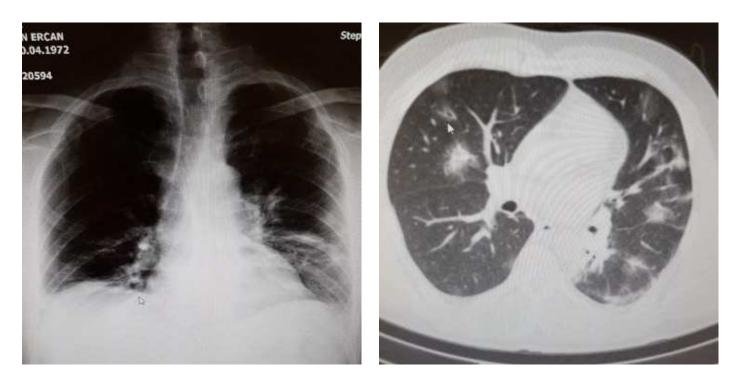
Hospitalization Chest X-ray
